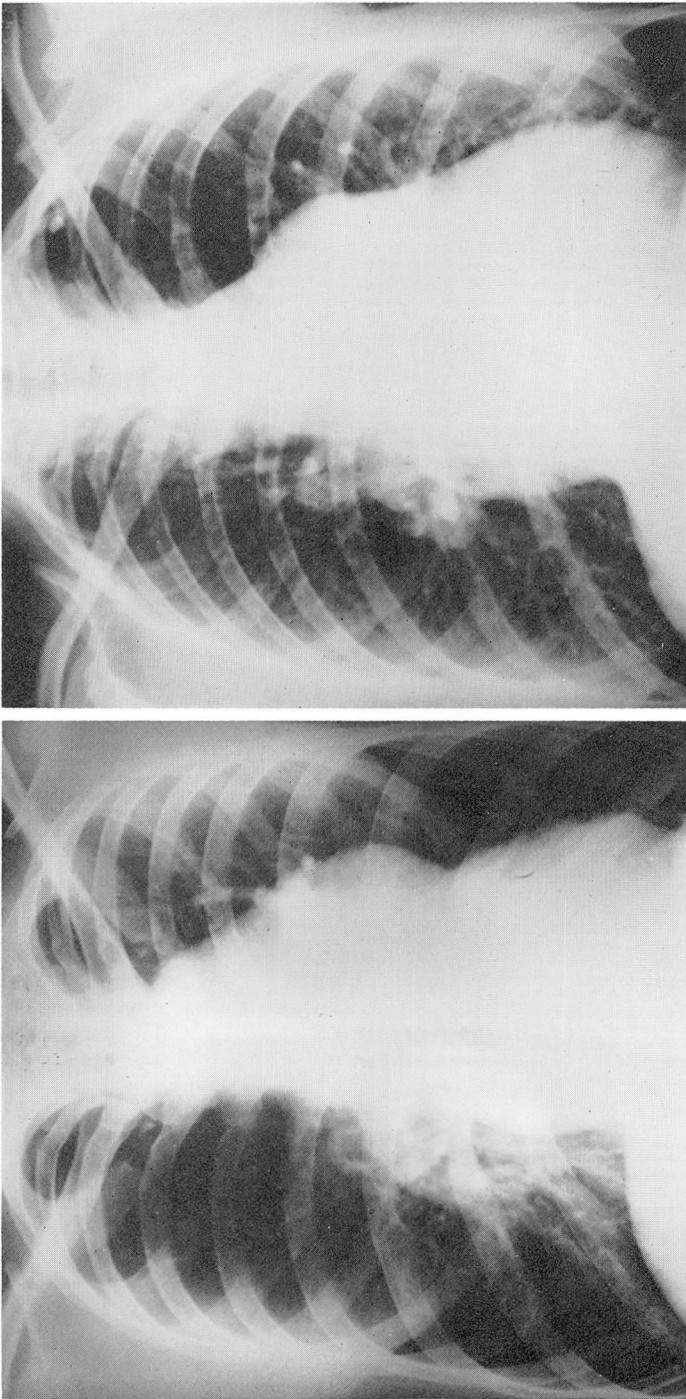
The two roentgenograms demonstrate the degree of aneurysmal enlargement which can occur in response to pulmonary hypertension. (a) The roentgenogram of the chest of the patient in whom the operation terminated in fatal hemorrhage. (b) The roentgenogram of the chest of the patient in whom hypotension was first utilized. Note the generalized increase in pulmonary vascular markings in addition to the aneurysmal enlargement of the pulmonary artery.
